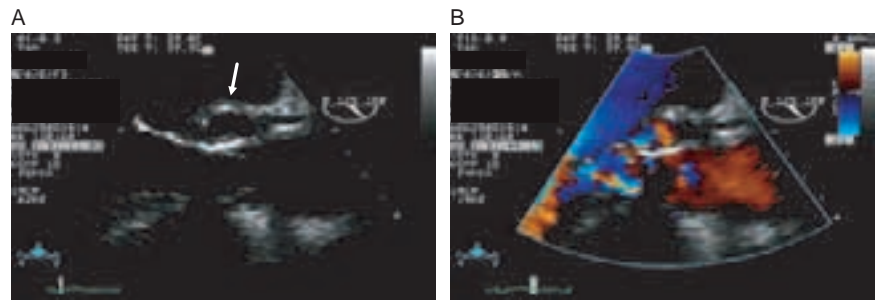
Transoesophageal echocardiography colour Doppler flow image of a patient with a mitral Björk–Shiley prosthesis (arrows) and infective endocarditis. Several paraprosthetic regurgitant turbulent jets are seen in the dilated atrium (LA). LV, left ventricle.
